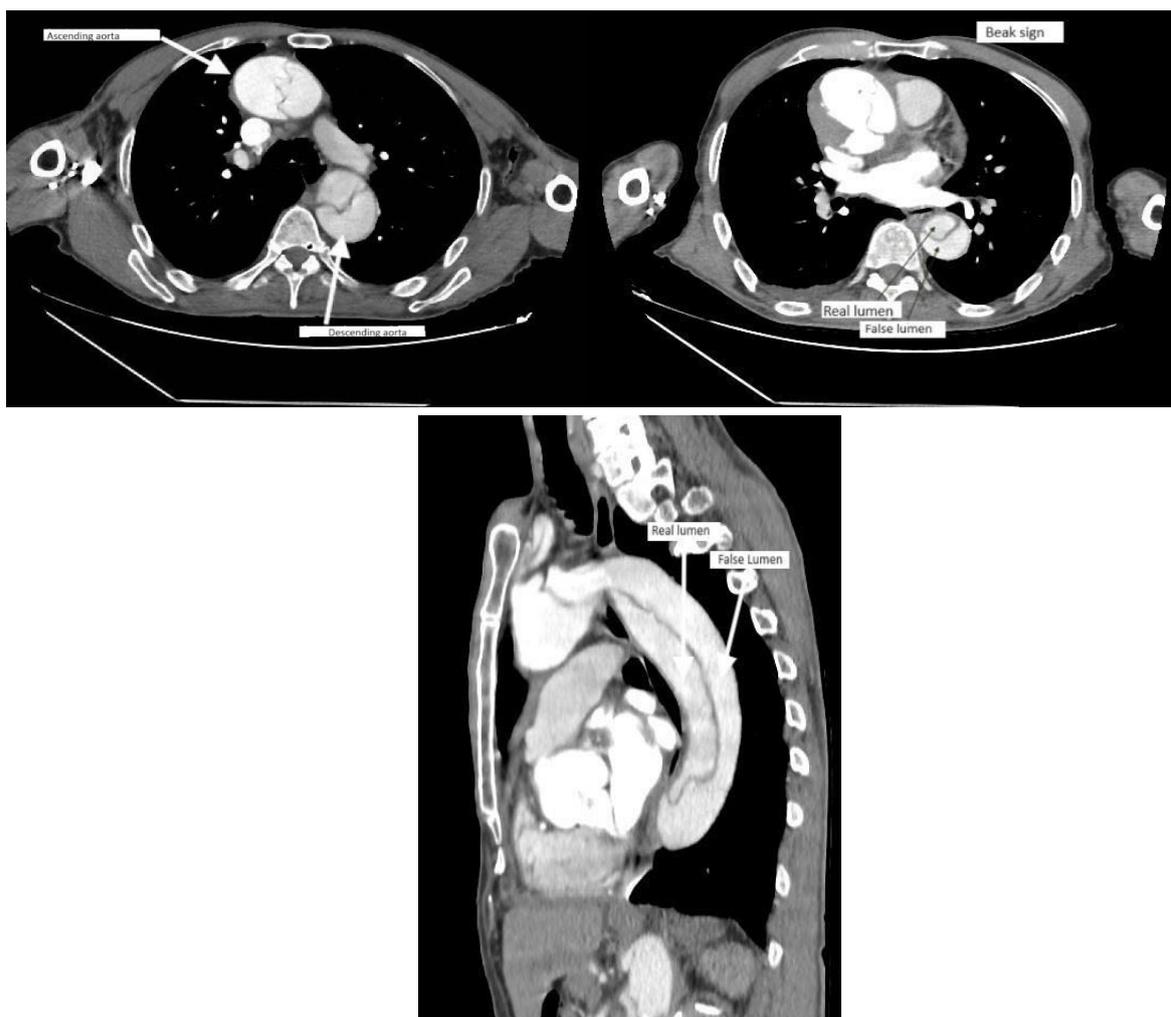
CT scan showing the extend of the aortic dissection with a beak sign
